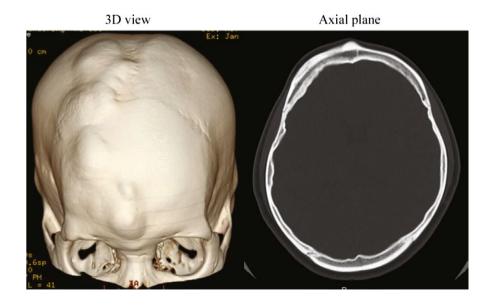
Head computed tomography scan at the preoperation. 3D view shows multiple lumps on right skull. Axial plane of bone image shows external bone hyperplasia
